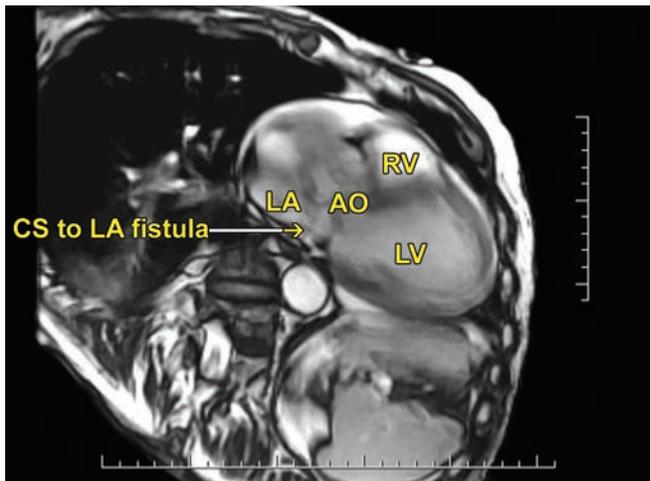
Cardiac MRI revealing the fistulous communication between the left atrium and the coronary sinus. (AO: Aorta; CS: Coronary sinus; LA: Left atrium; LV: Left ventricle).
